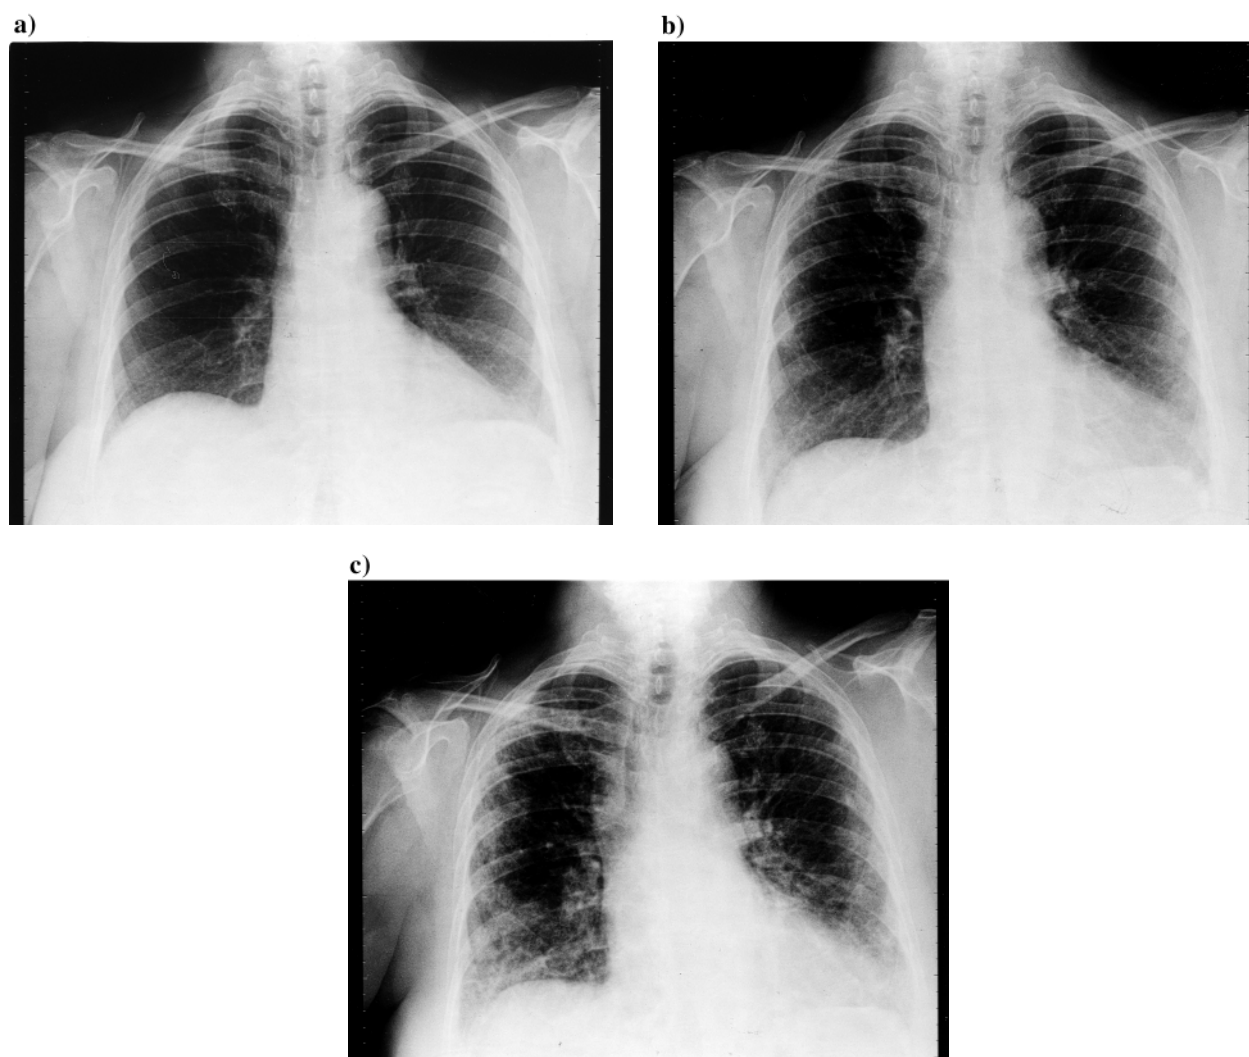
Chest roentgenogram a) before, b) after 7 and c) after 8 courses of Raltitrexed.
